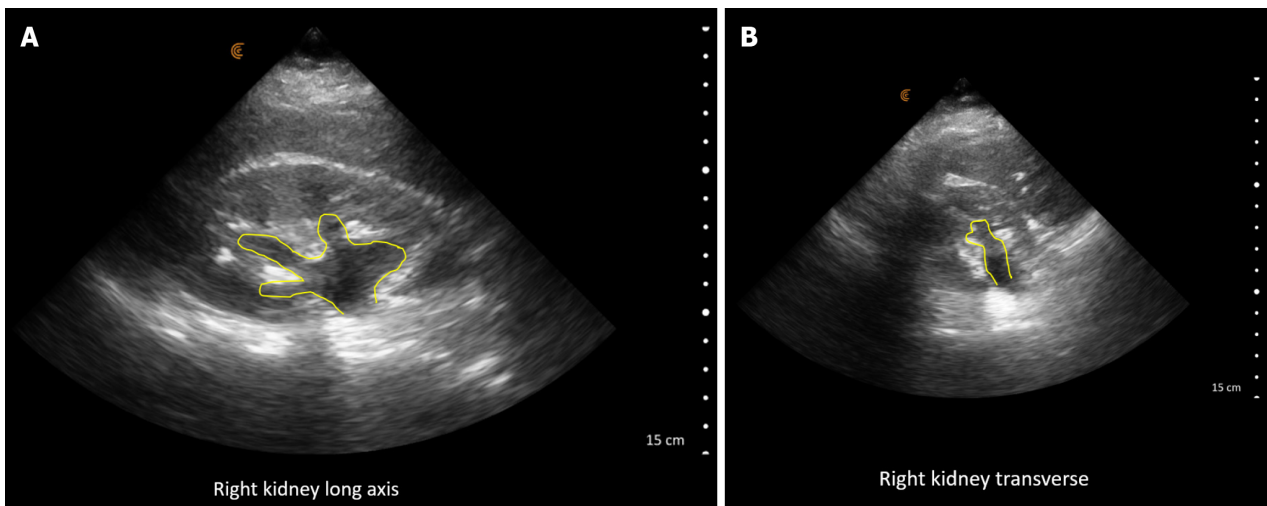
Renal ultrasound images demonstrating. A: Long axis views of right hydronephrosis (yellow outline); B: Short axis views of right hydronephrosis (yellow outline).
